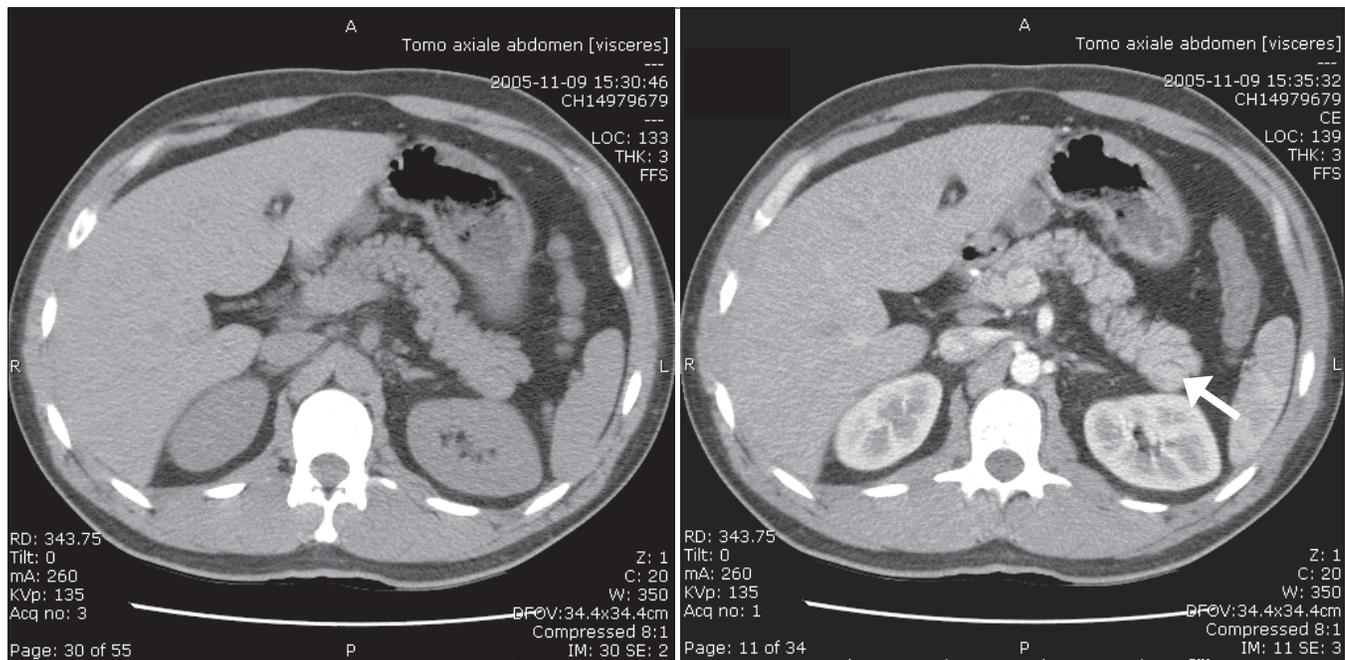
Computed tomography scans of the patient's abdomen without (left) and with (right) intravenous contrast in the arterial phase showing an ovoid lesion that appears more dense than the adjacent pancreatic tissue (white arrow).
